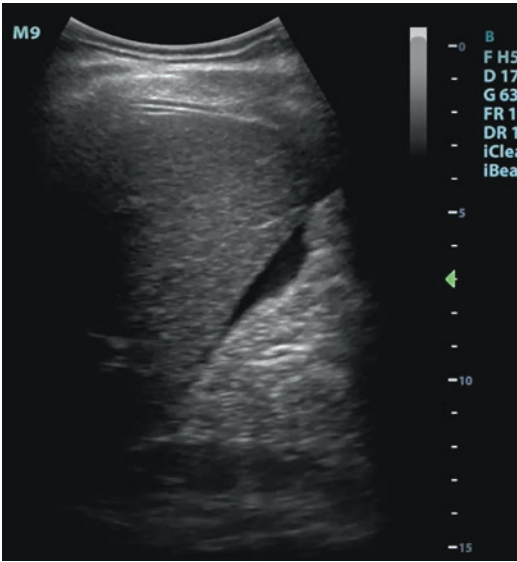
Extended Focused Assessment with Ultrasound in Trauma (E-FAST) scan showing free fluid surrounding the liver border in a polytrauma patient (Reproduced with permission of Huang and Fung)
